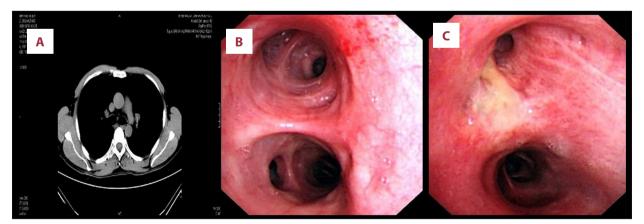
At the completion of treatment, CT (A) and bronchoscopy (B, C) both showed disappearance of the tumor.
